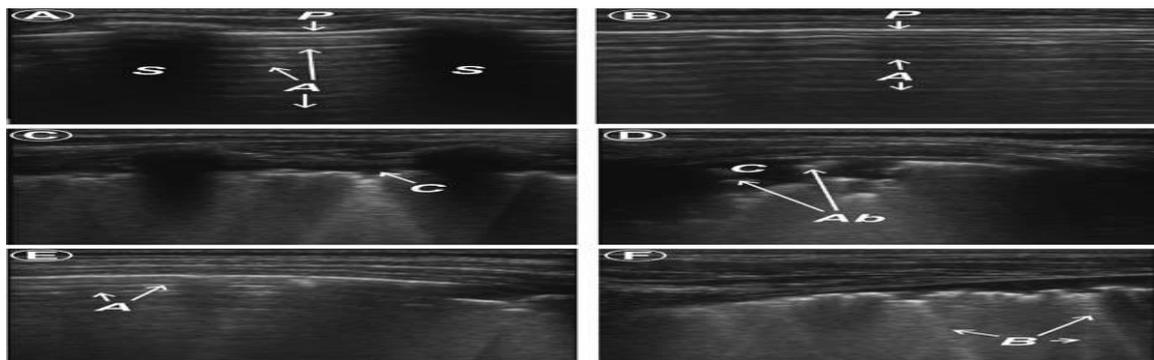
Lung sonographic signs associated with anesthesia- induced atelectasis.
